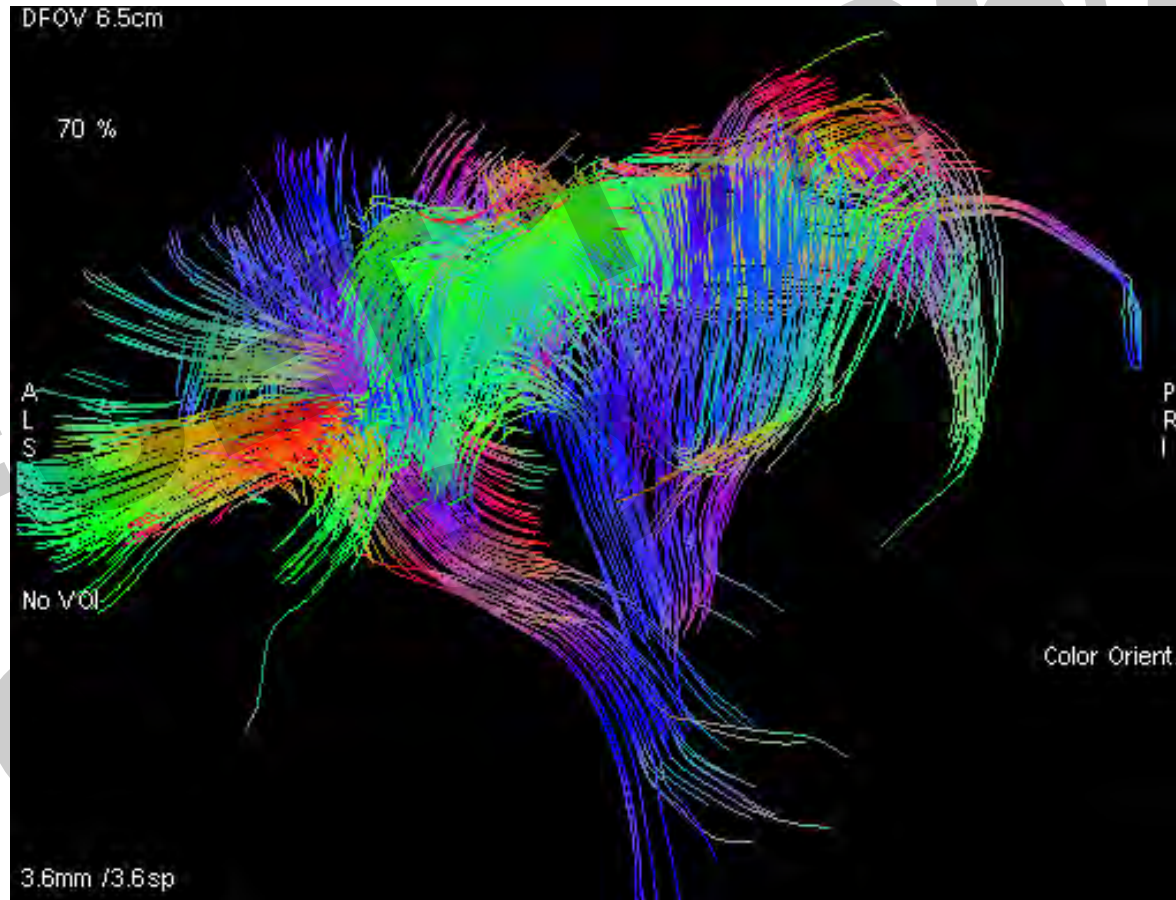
Axial T2-weighted magnetic resonance images of fetus at 28 weeks of gestation showing three-dimensional fiber tracts projected onto the fetal brain. Note the genu and the splenium of the corpus callosum (blue) and the corticopontine/corticospinal projection fibers (green).
